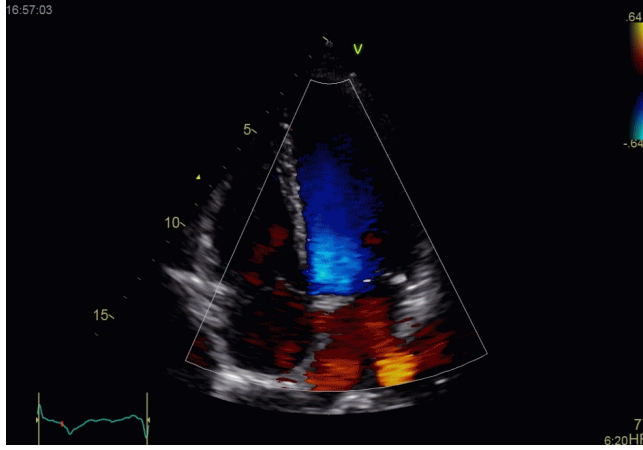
Example of duplex mode ultrasound imaging. Reproduced with permission from <http://folk.ntnu.no/stoylen/strainrate>.
